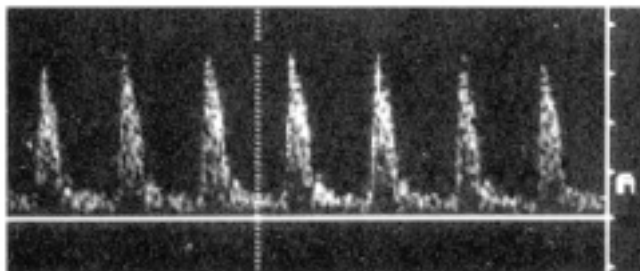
Postoperative Doppler waveform tracing for patient with LIMA graft with graft occlusion at 2 weeks
